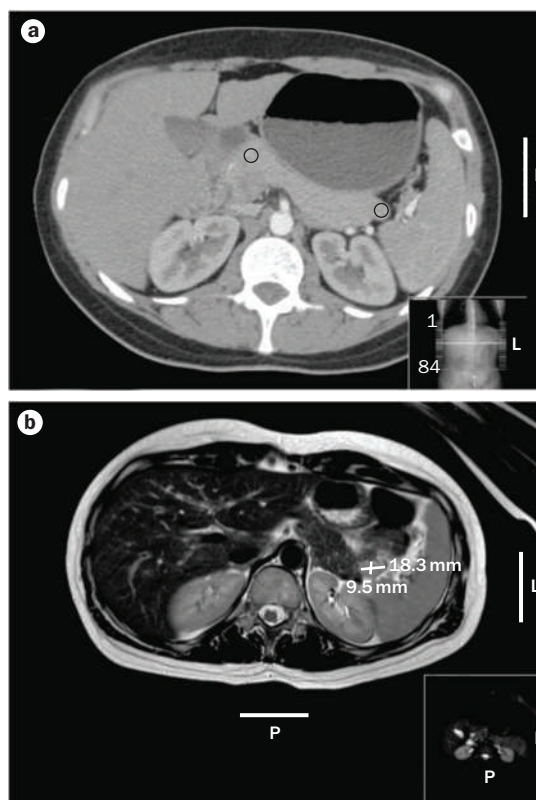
Localization of a possible insulinoma in the case patient. a | CT scan of the abdomen of the patient described showing nodular pancreas but no differential enhancement after contrast. b | MRI scan of the abdomen showing a 18.3 mm by 9.5 mm enhancing islet cell tumor within the tail of the pancreas.
